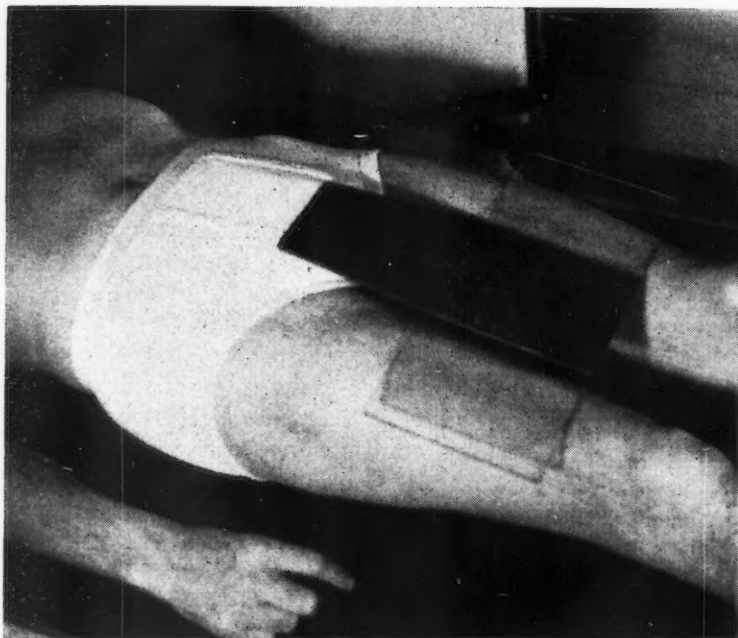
Position of Ardran lead gonad shield during radiography.
